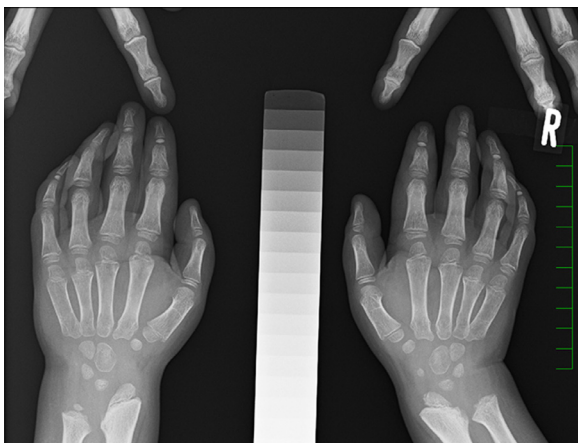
A hand radiograph at 12 years of age showing decreased bone density, delayed carpal ossification, and proximal pointing of the metacarpals.
